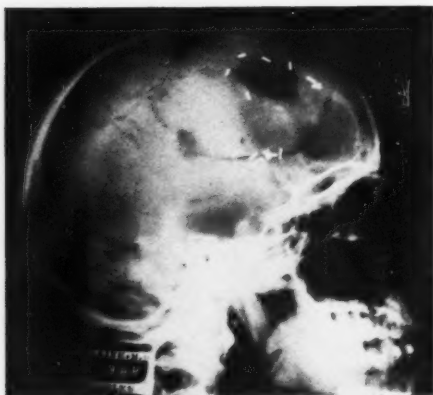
A bone flap resected around a cranial defect for operative removal of a post-traumatic cyst. This x-ray, taken one and a half years later, reveals a filling in of the cut edges of bone, the normal appearance of the bone within the flap, the defect due to the depressed fracture, the defects caused by burr openings, and the presence of innumerable silver clips placed upon the cerebral vessels when the cyst was removed.
